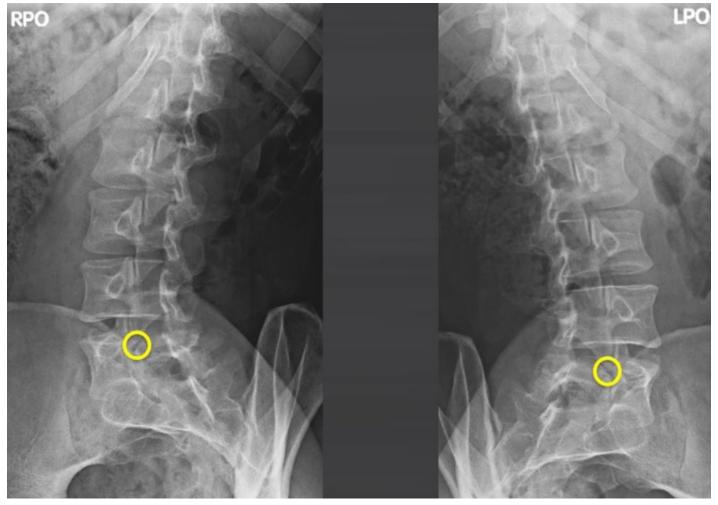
(a). Lumbar oblique radiographs of the same subject scanned in Figure 5b demonstrating bilateral pars defects (yellow circle) at L5.
